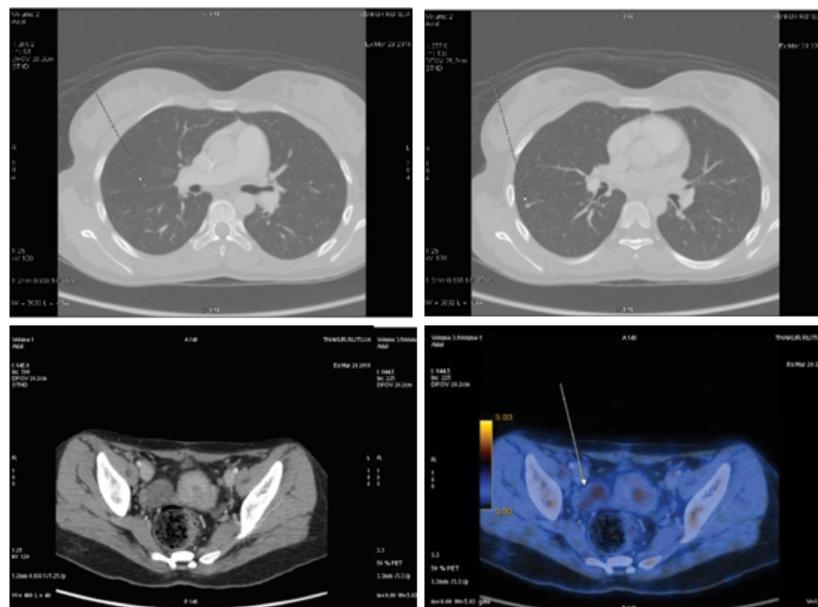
PET CT SCAN images showing tiny FDG non-Avid lung nodules and ill defined FDG non Avid hypodense lesion in right adnexa
